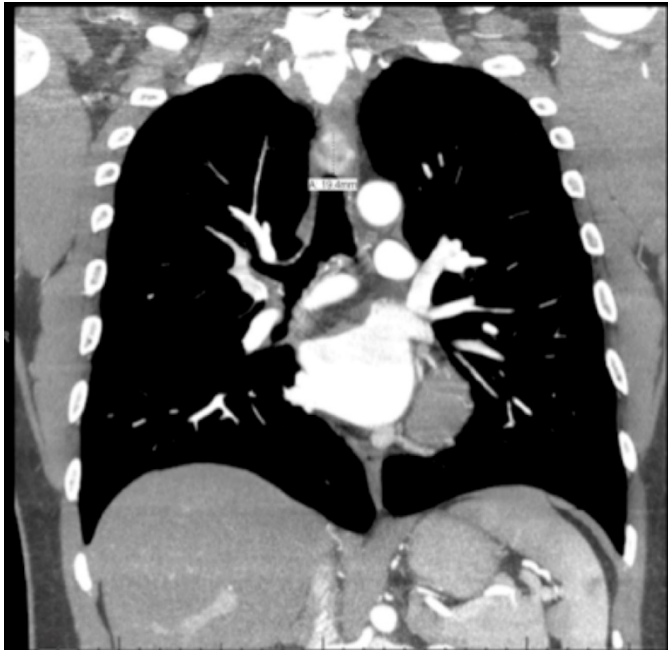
Computed Tomography appearance of tracheal mass
